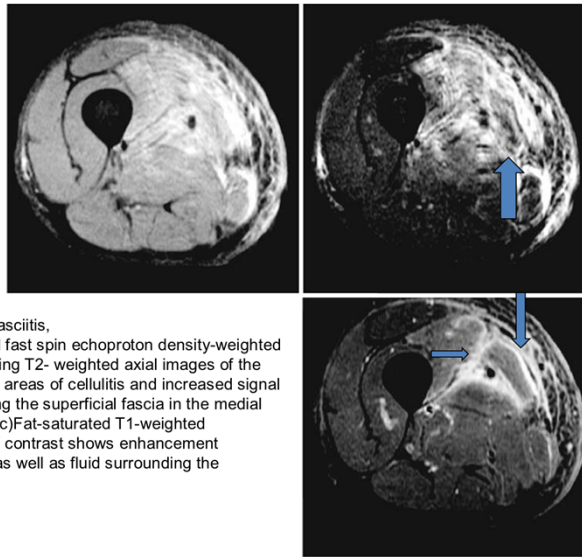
Necrotizing fasciitis, early. Fat-saturated fast spin echoproton density-weighted (a) and corresponding T2- weighted axial images of the right thigh (b) show areas of cellulitis and increased signal intensity surrounding the superficial fascia in the medial aspect of the thigh(c)Fat-saturated T1-weighted axial image after IV contrast shows enhancement of the deep fascia as well as fluid surrounding the superficial fascia
